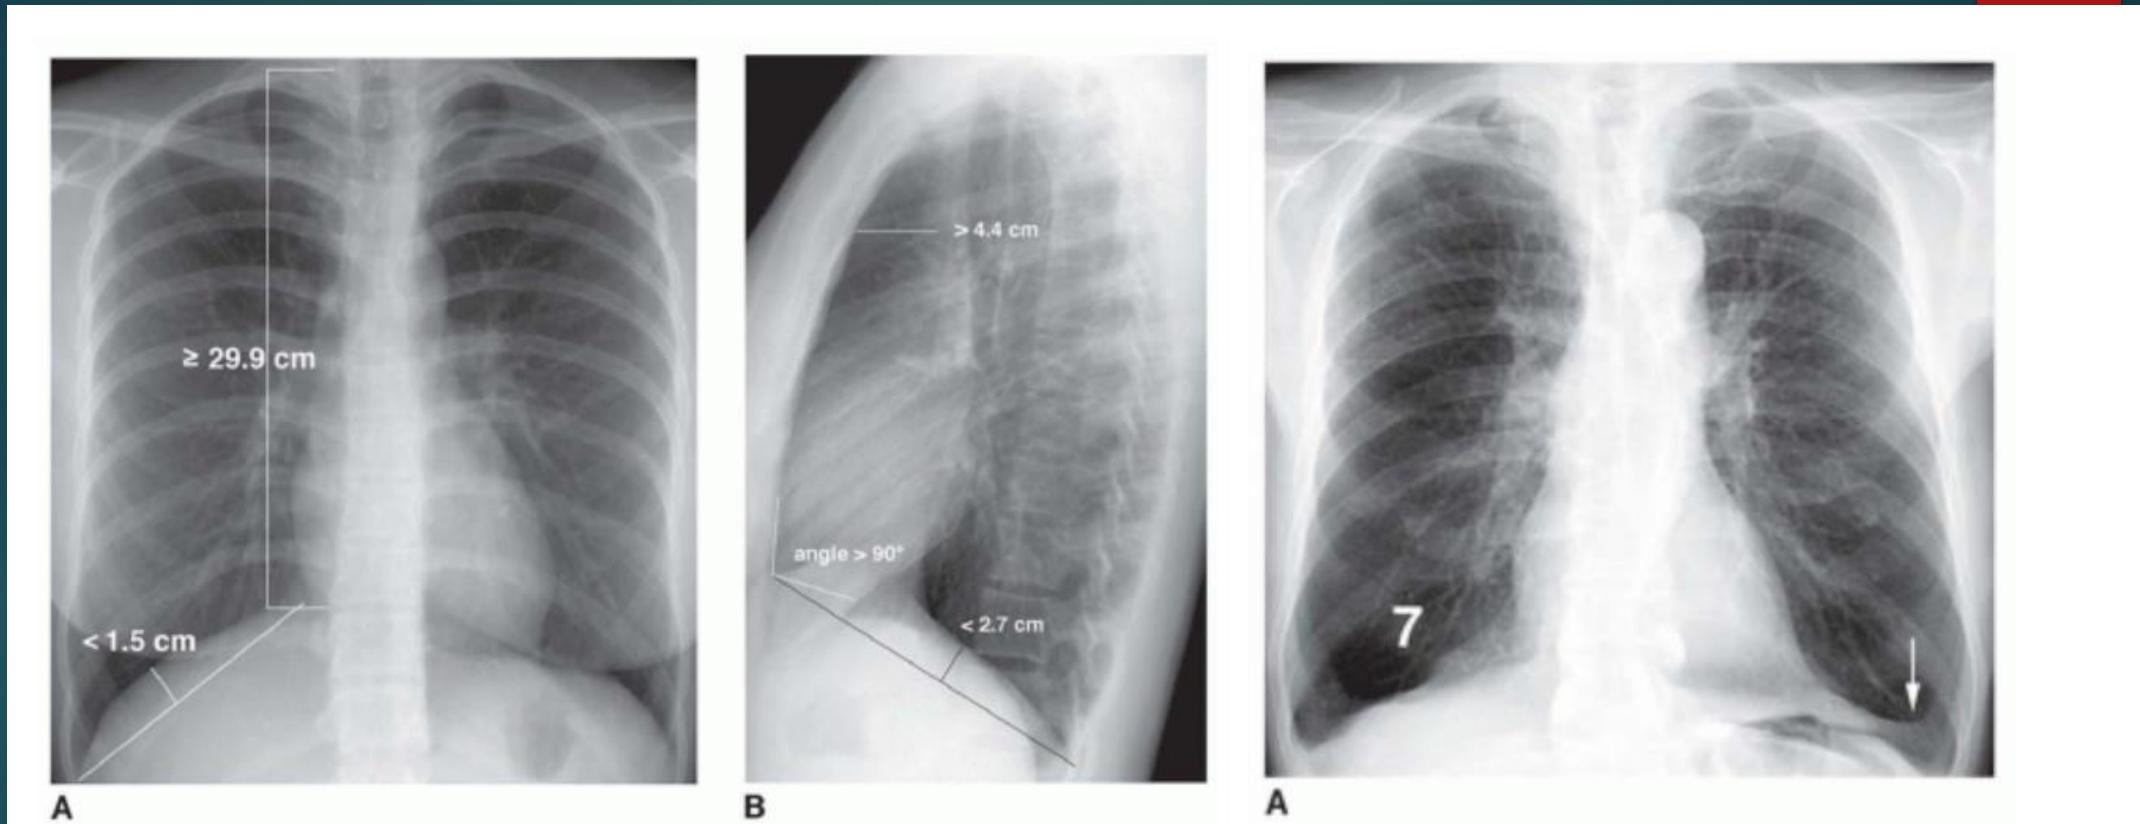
Plain film measurements in emphysema. A: Plain radiographic findings of emphysema on the PA radiograph include a lung height of 29.9 cm or more, measured from the dome of the right diaphragm to the tubercle of the first rib and flattening of the right hemidiaphragm on a posteroanterior radiograph, with the highest level of the dome of the right hemidiaphragm less than 1.5 cm above a perpendicular line drawn between the costophrenic angle laterally and the vertebrophrenic angle medially. B: Findings of emphysema on the lateral radiograph include flattening of the right hemidiaphragm, with a height of less than 2.7 cm measured from anterior to posterior costophrenic angles; an increased retrosternal air space, measuring more than 4.4 cm at a level 3 cm below the manubriosternal junction; and a sternodiaphragmatic angle measuring 90 degrees or more.
